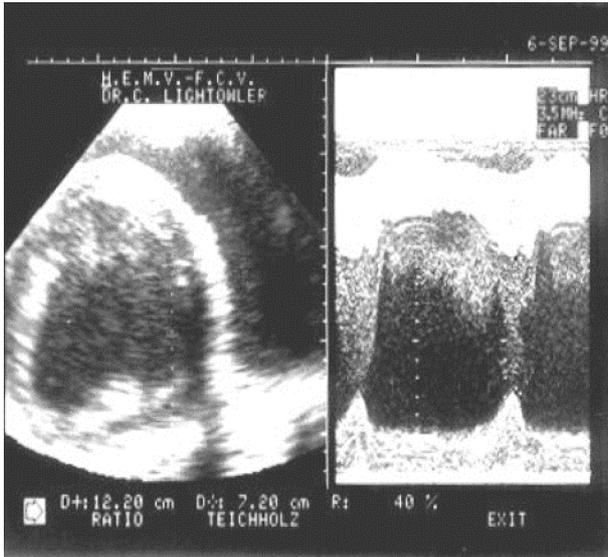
Right parasternal window. Image captured in order to infer the measurements to calculate LVMM. Left: 2D view in short axis, at the chordae tendineae level. Right: guided M-Mode view.
